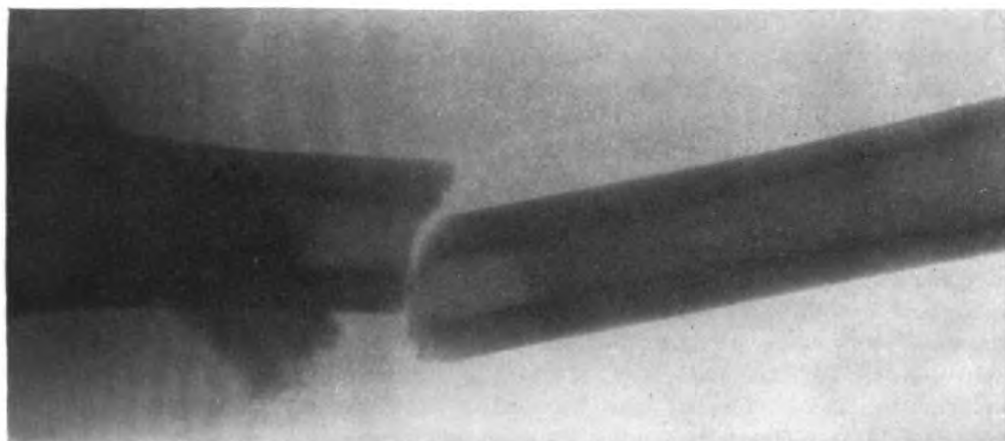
Case 1. Preoperative lateral x-ray.
